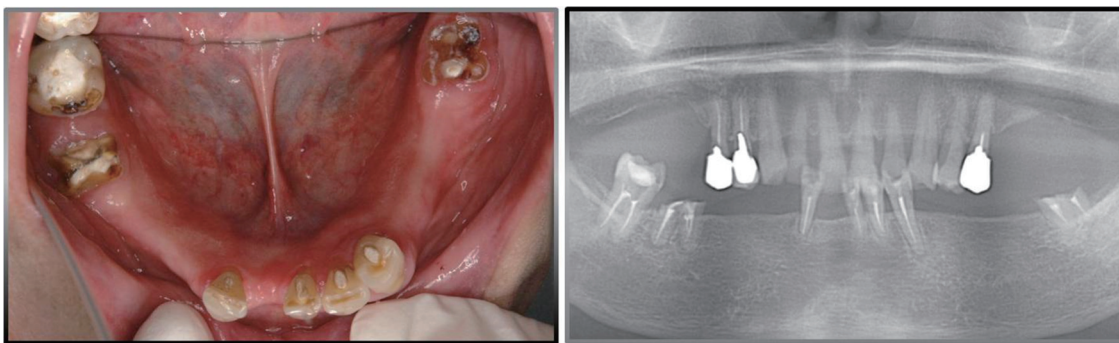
Intraoral image and panoramic X-ray at the completion of the root canal treatment
